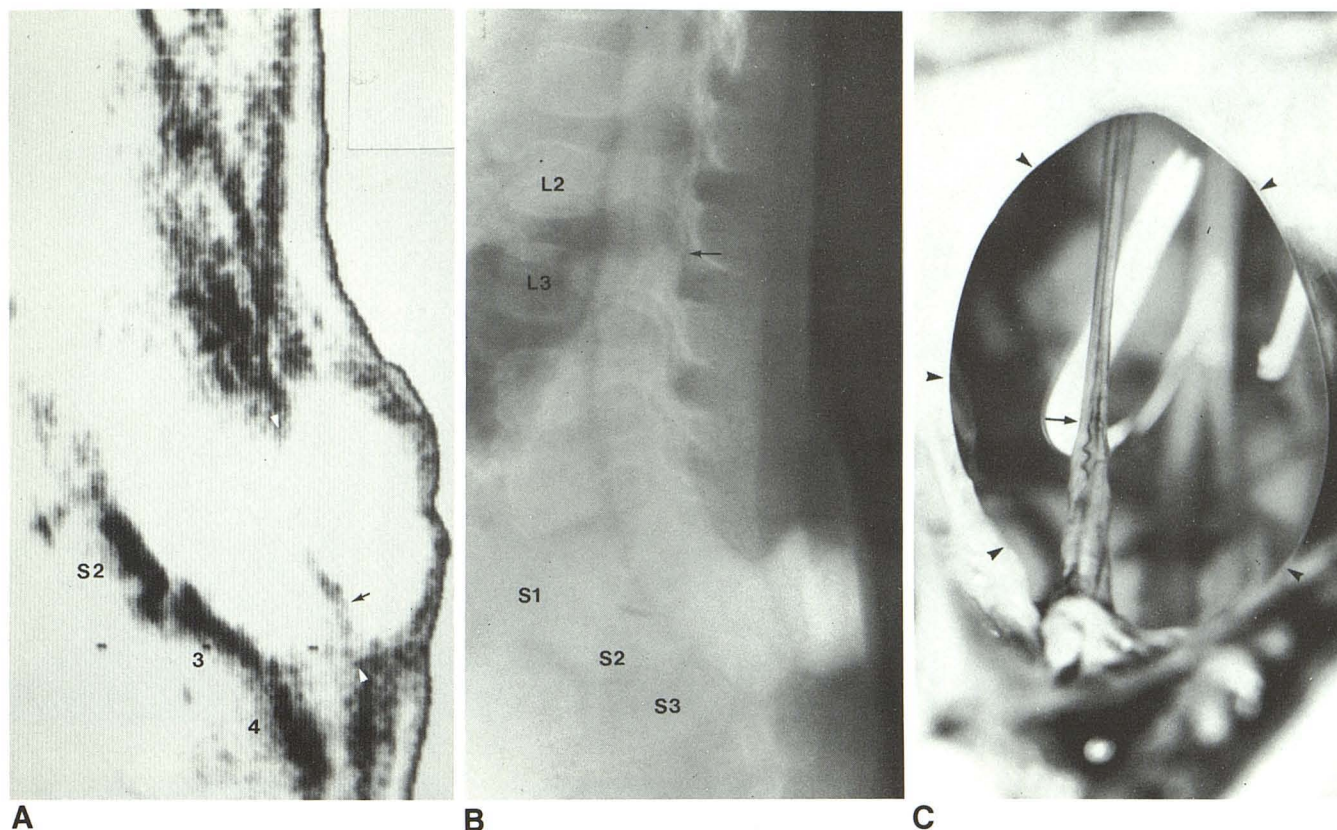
Simple meningocele, 1-year-old girl. A, Midsagittal sonogram demonstrates sacral vertebrae (S2–S4) and absence of posterior sacral elements at S1–S3, indicating focal sacral spina bifida. Lumbosacral mass is large anechoic meningocele directly continuous with enlarged spinal canal through relatively narrow hernia ostium (arrowheads). Thin wall of sac and absence of internal echoes signify this is a simple meningocele not associated with tethered cord. Filum terminale (arrow) passes to lower edge of hernia ostium. B, Lateral
